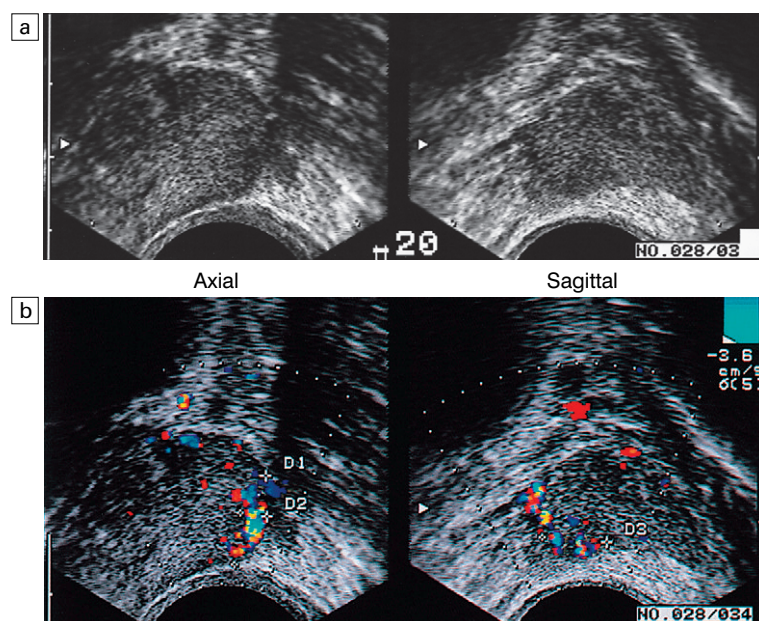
Peripheral zone prostate cancer. (a) Axial and sagittal grey-scale images demonstrate a subtle hypoechoic area in the left neurovascular bundle (arrows). Biopsy through this area was positive for adenocarcinoma, Gleason score 6. (b) Axial and sagittal colour Doppler images at corresponding locations demonstrate increased colour flow in areas involved by tumour.
